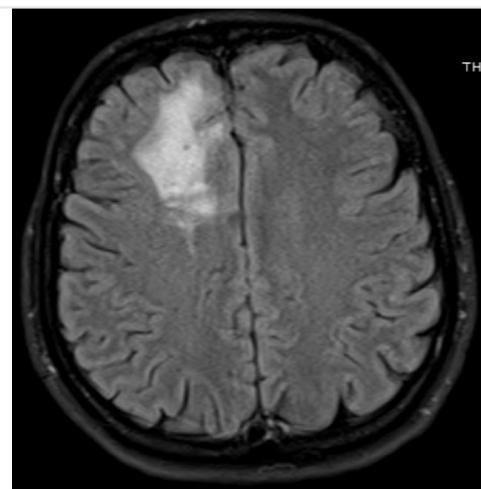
Progression in pre-operative axial T1 weighted FLAIR magnetic resonance image
